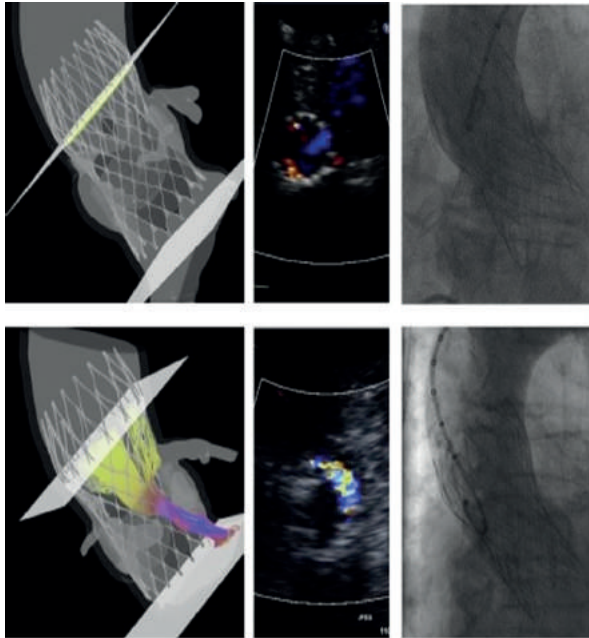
Top row: example of a prediction model of a patient in which no PVL was predicted corresponding well with echocardiography and angiography (both grade 0).
